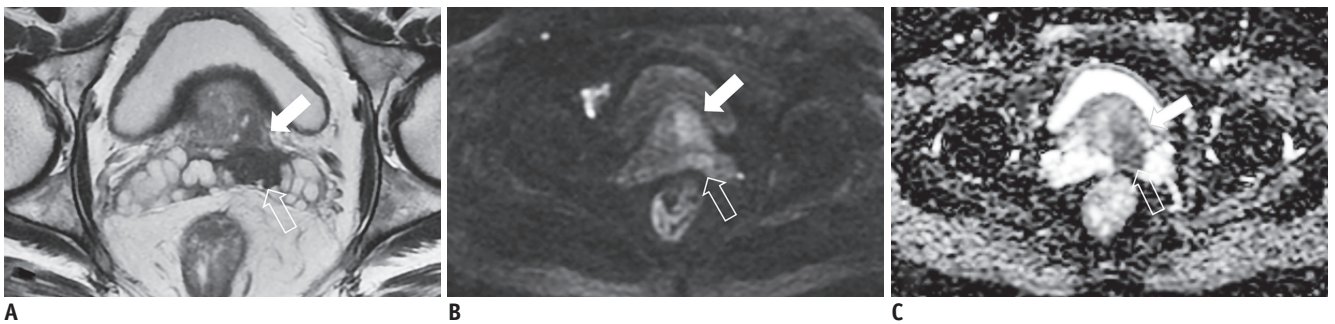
MRI report of this case was generated in structured format of report B.
